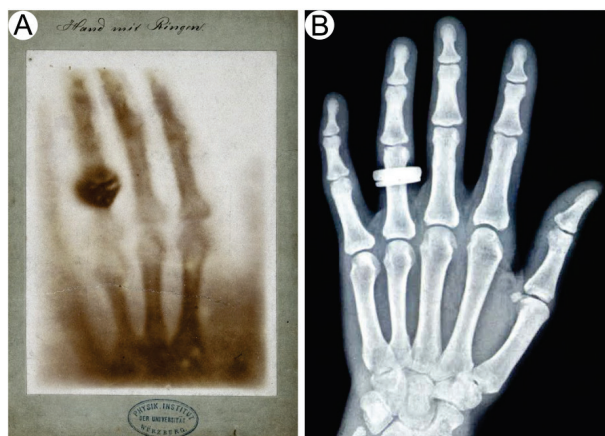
Historical perspectives in X-radiography. X-ray radiographs of (A) a of hand made by W.C. Röntgen on December 22, 1895 (original plate is in the Deutsche Museum, Munich, Germany), and (B) of a patient's hand made in 1995 at the Mayo Clinic ((Rochester, MN). Image courtesy of R.A.Robb.⁶
